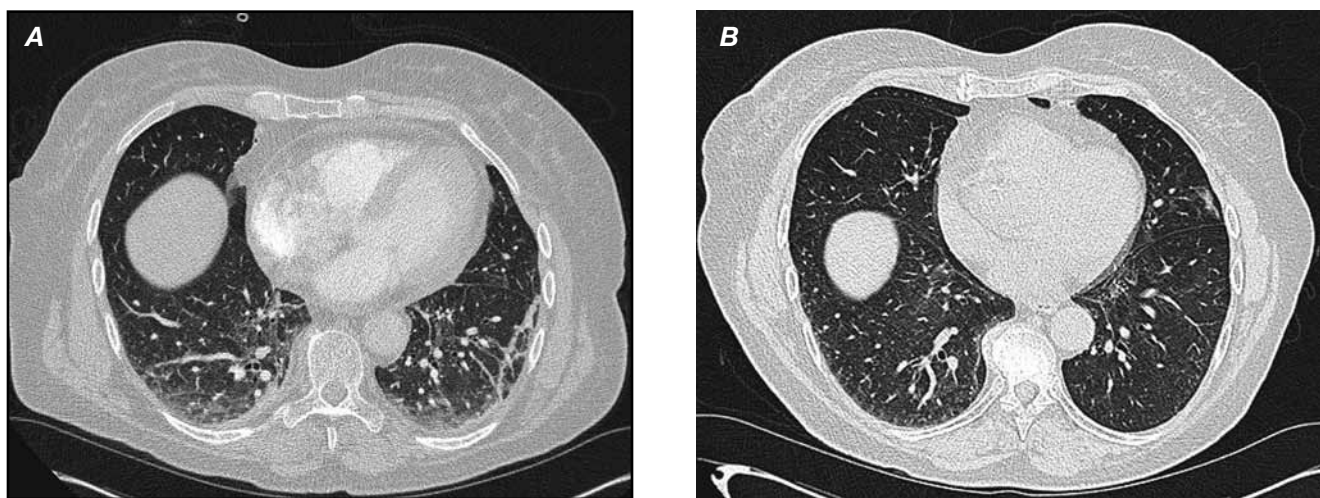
(case 1). Computed tomographic images of lung bases before (A) and after (B) thyroxine replacement in a 68-year-old woman with severe hypothyroidism.
